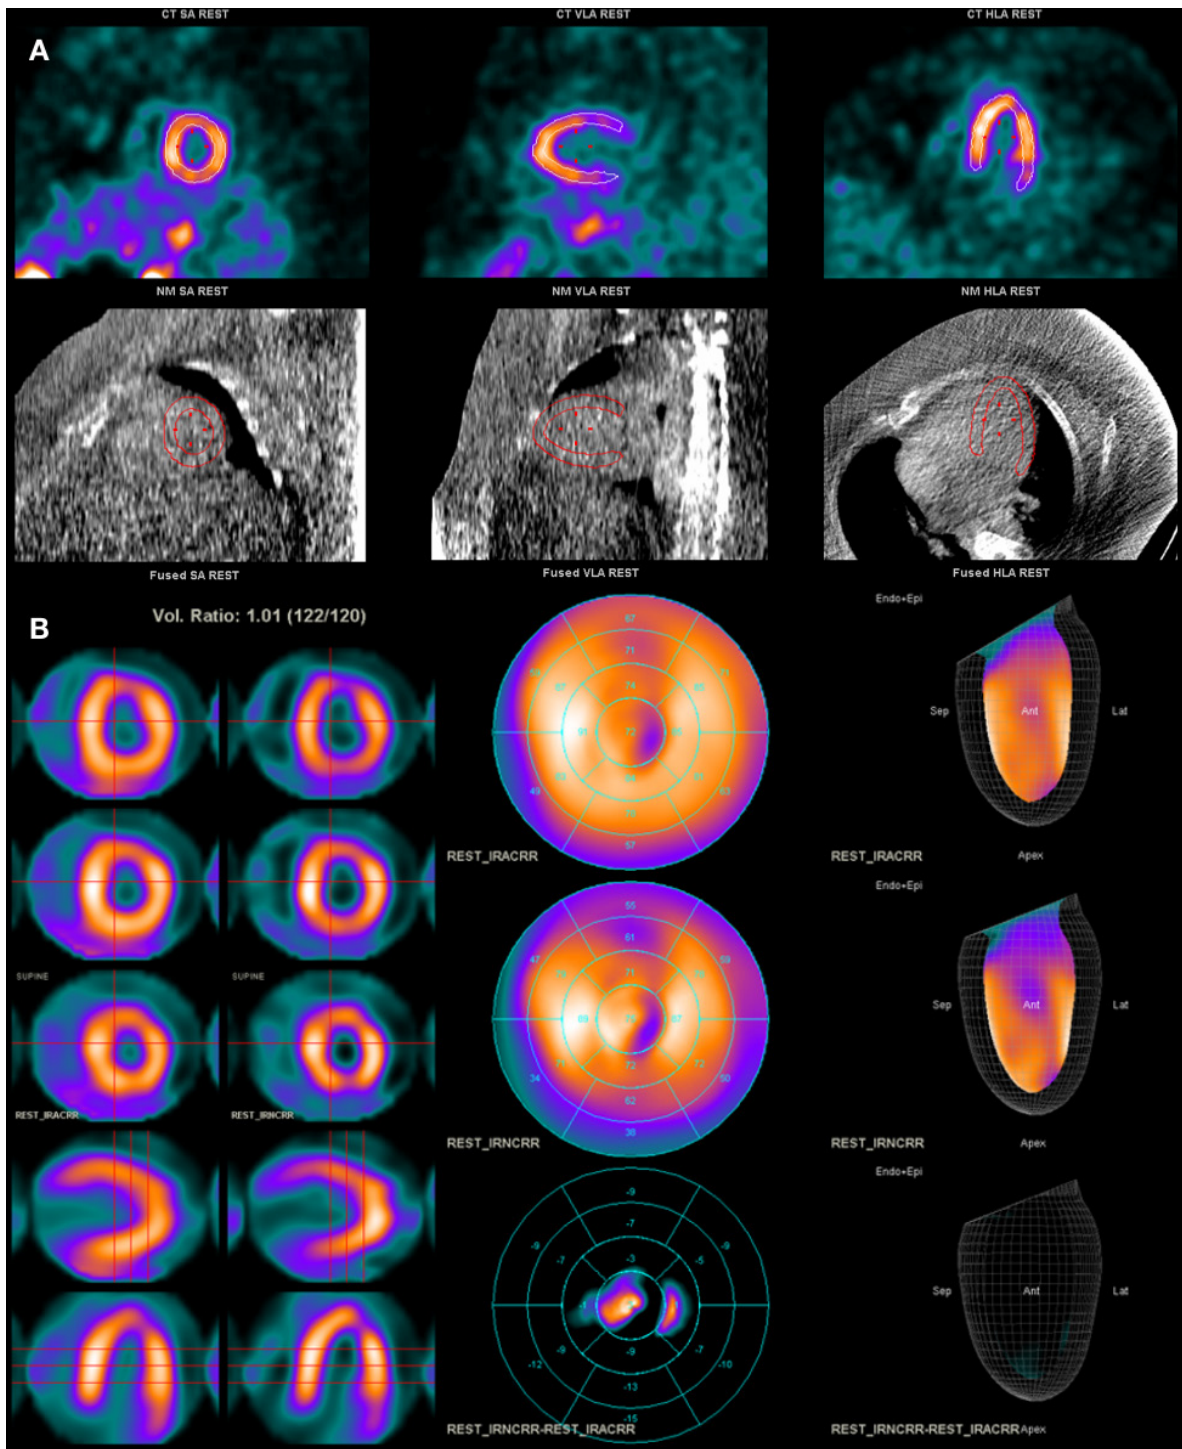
(A) Myocardial perfusion SPECT/CT study showing good registration between the emission and CT for attenuation scan and (B) the resulting AC (IRACRR) and NAC (IRNCRR) reconstructed images and polar maps from this registration.
